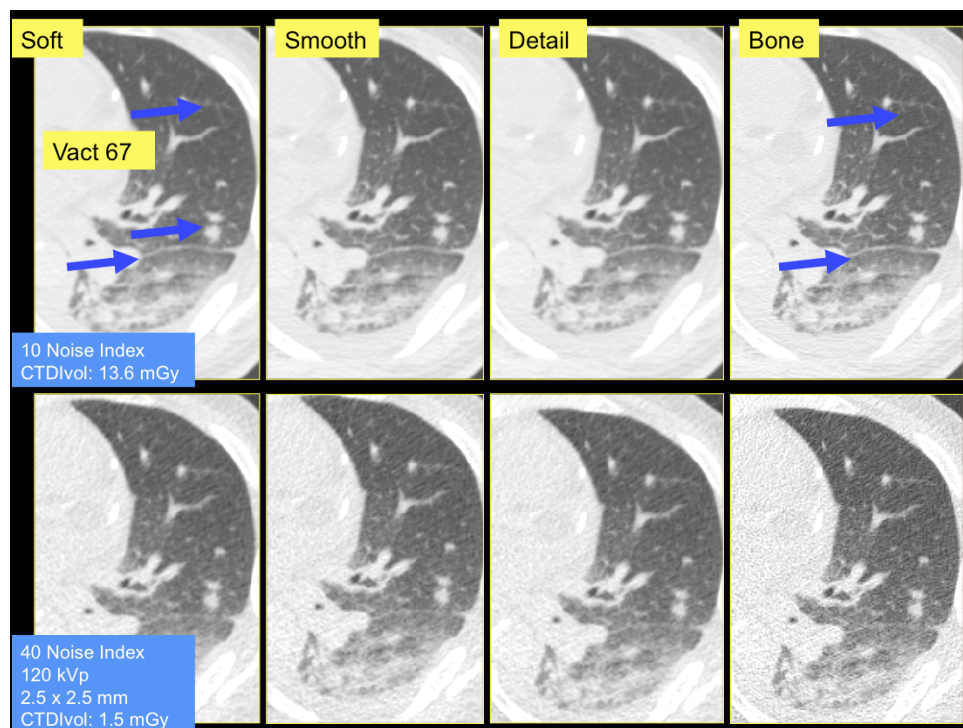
Transverse chest CT images acquired at two dose levels (higher dose: 10 noise index (upper
